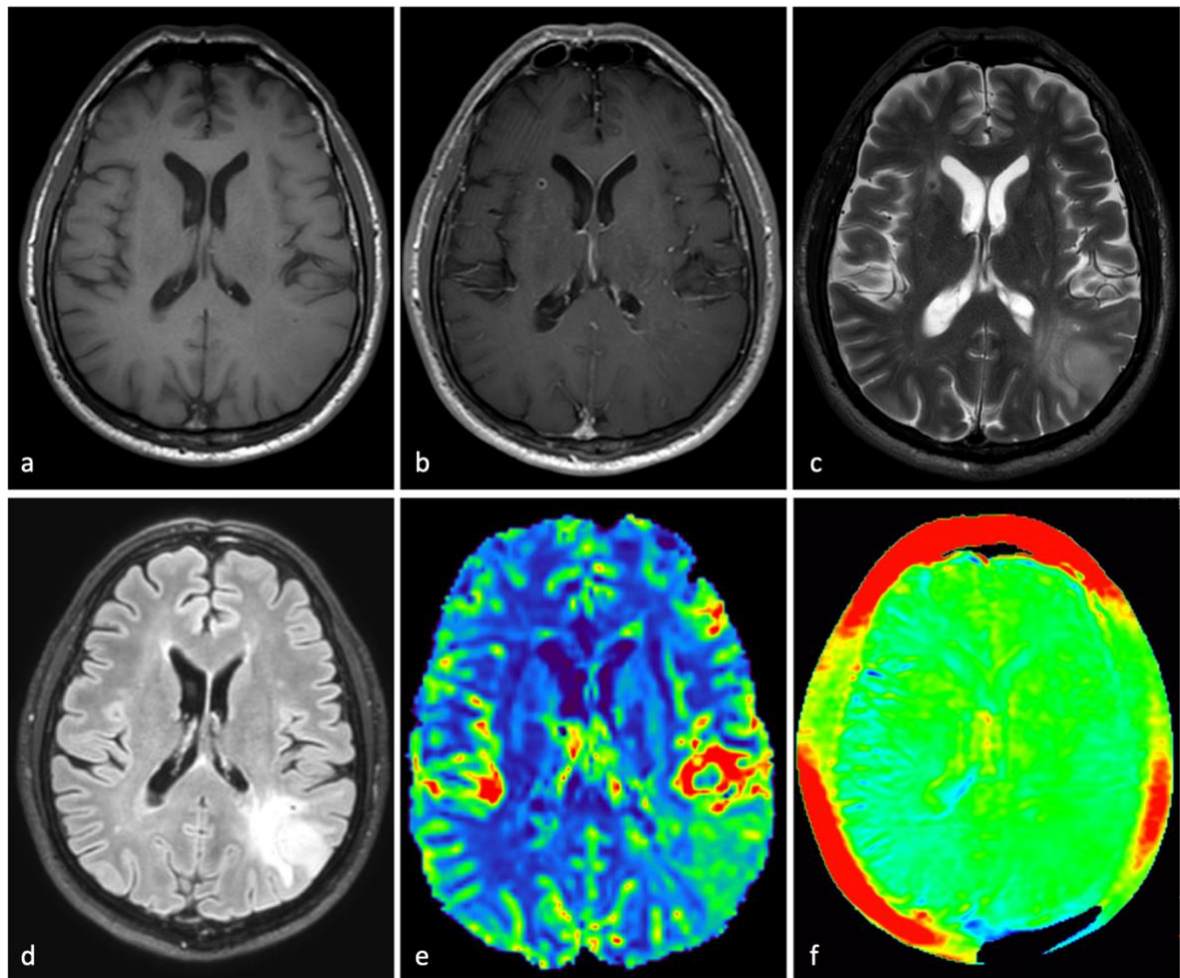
MR images of patient 5, with a low-grade glioma. a. T1-w image. b. Gd-T1w image. c. T2-w image. d. T2-FLAIR image. e. DSC perfusion study. f. APT-w image.
